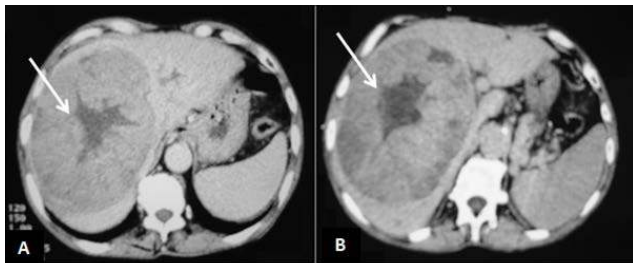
Axial abdominal CT without contrast injection (hepatic dome (A) and hepatic hilum (B) sections): large and heterogeneous liver tumor with central scar
